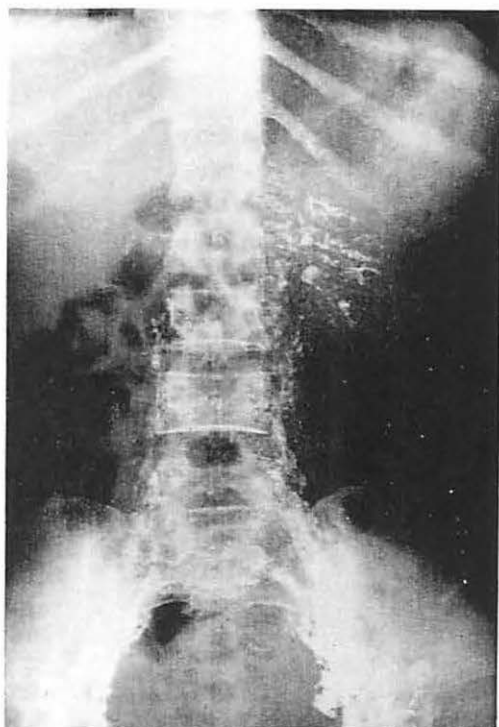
Repeat X-ray of Fig. 6 taken seven days after lymphography showing the contrast clearing from lymph nodes and retroperitoneal lymphatics but the contrast remained within the fistulous communications.
